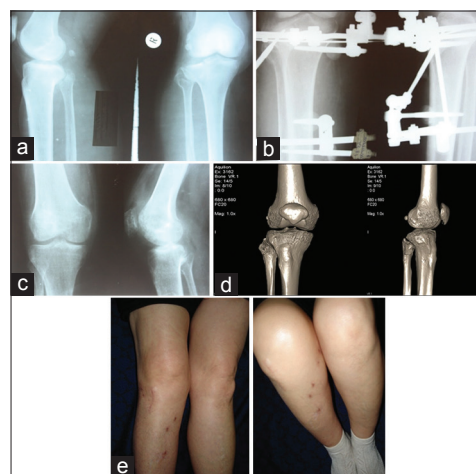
The radiographs and the photographs of the patient Ch., born in 1954, m/r 2465 (a) before treatment, type of injury, (b) during treatment in external fixation device, (c) the immediate outcome of treatment, (d) RKT 3 years after injury, (e) clinical outcome of joint function treatment-restoration
